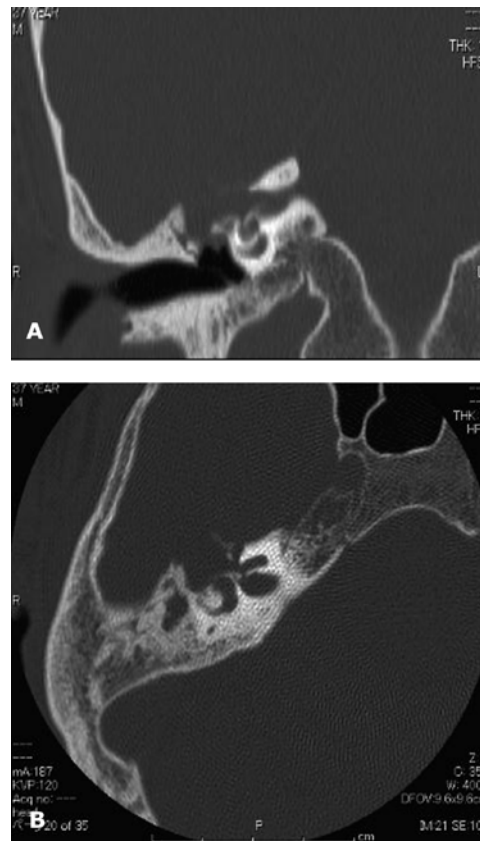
CT findings. a: epi-tympanic mass lesion with bony erosion; b: small cochlear fistula.
